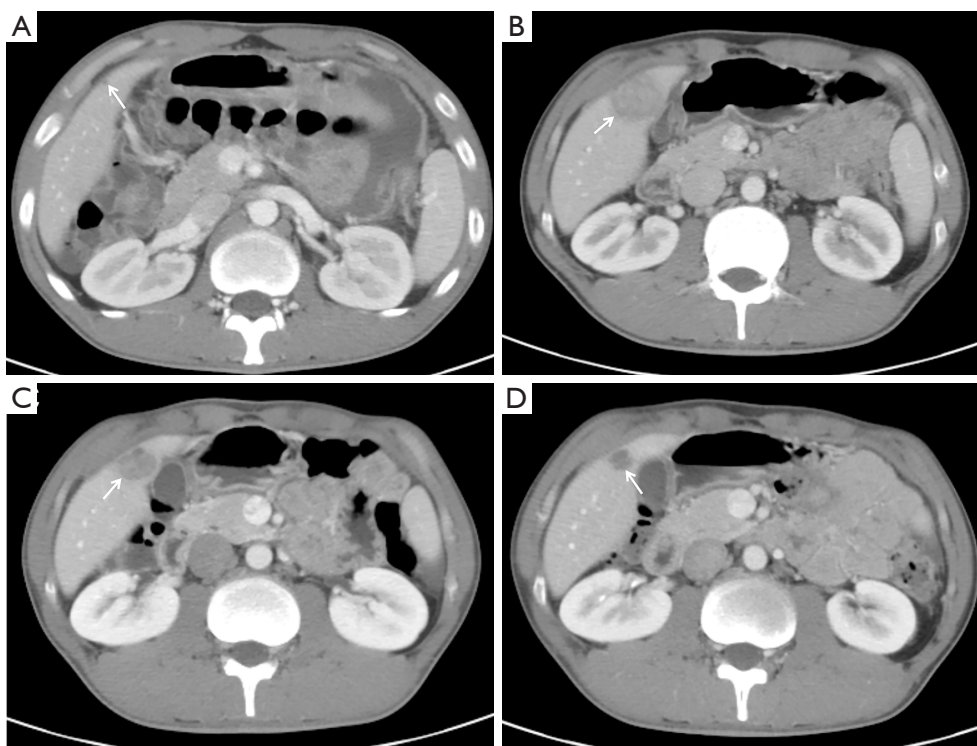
A 23-year-old male patient diagnosed with pulmonary and peritoneal tuberculosis. Both the *Mycobacterium tuberculosis* culture and molecular diagnostic tests were negative. A peritoneal biopsy from another hospital revealed chronic granulomatous inflammation with caseous necrosis. (A) An abdominal contrast-enhanced computed tomography scan in the portal venous phase, conducted on December 16, 2019, showed thickening and ring enhancement of the perihepatic peritoneum and hepatic capsule (not shown in the image), along with a small nodule in the lower segment of the right anterior lobe of the liver (as indicated by the white arrow). The initial computed tomography findings were classified as mixed type. (B) A follow-up computed tomography scan, conducted on March 10, 2020, revealed no significant changes in the thickening and ring enhancement of the perihepatic peritoneum and hepatic capsule (not depicted in the image), but the nodule in the lower segment of the right anterior lobe of the liver had significantly enlarged, and was accompanied by a thickening of the adjacent peritoneum and hepatic capsule (as indicated by the white arrow), indicative of a paradoxical reaction. (C) A subsequent computed tomography scan, conducted on May 26, 2020, showed a reduction in the size of the lesion in the lower segment of the right anterior lobe of the liver, but the thickening of the adjacent peritoneum and hepatic capsule persisted (as indicated by the white arrow). (D) A final follow-up computed tomography scan, conducted on December 9, 2020, showed a further reduction of the lesion in the lower segment of the right anterior lobe of the liver, and a decrease in the enhancement density (as indicated by the white arrow).
